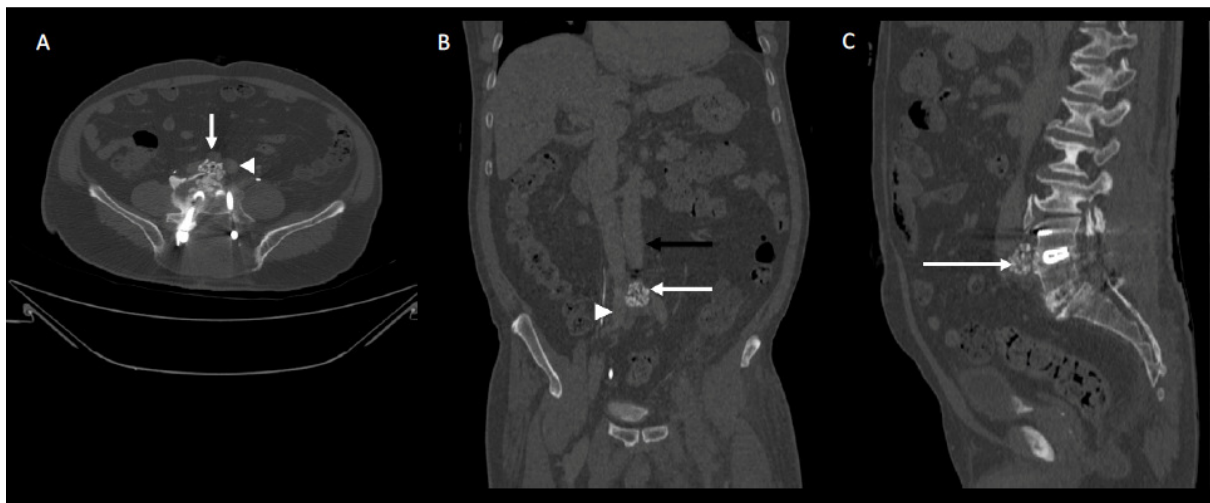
The 3-D computed tomography (CT) angiography at L4-5 on postoperative day 17
